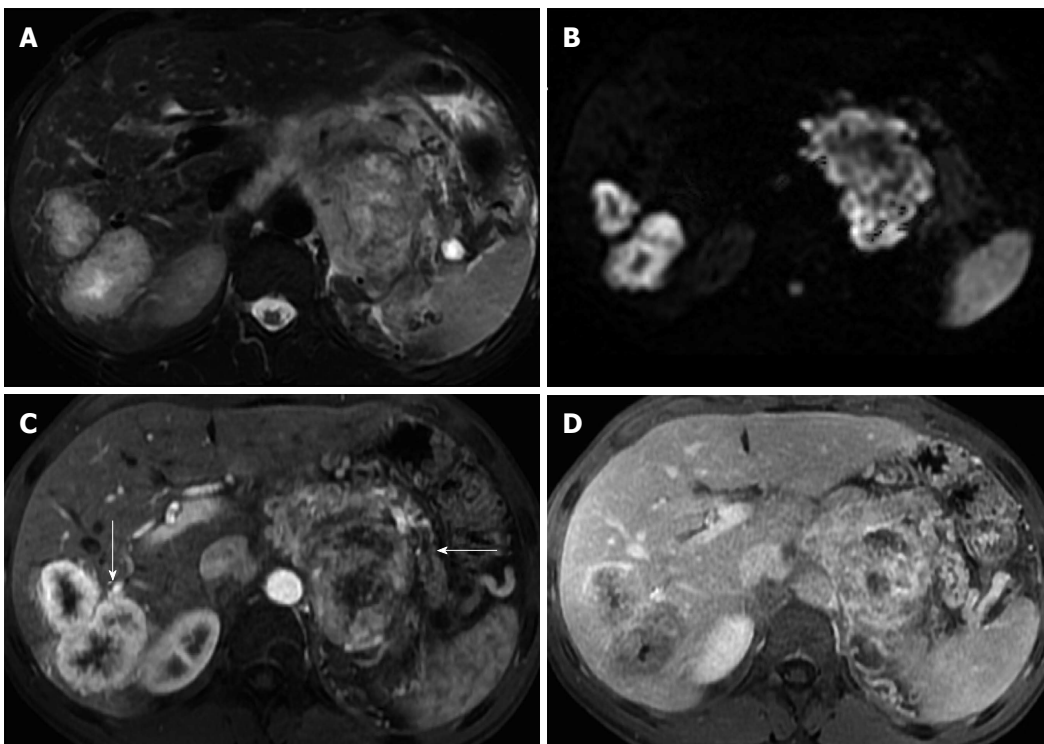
Pancreatic neuroendocrine tumor and liver metastases. Axial T2-weighted SS-ETSE (A), diffusion weighted images ($b = 500$) (B) and post-gadolinium fat-suppressed T1-weighted GRE images acquired in the arterial (C) and venous (D) phase of enhancement. A large mass is seen arising in the body and tail of the pancreas, showing moderate signal intensity on T2-weighted images (A) and restriction to diffusion (B). This lesion shows hypervascular characteristics (C). This mass was diagnosed as poorly differentiated neuroendocrine tumor. Note that the liver metastases show similar signal characteristics on T2- and diffusion-weighted images and demonstrate the characteristic arterial wash-in (arrow, C) and late washout (D) seen with neuroendocrine tumor metastases. SS-ETSE: Single-shot echo train spin echo; GRE: Gradient echo.
